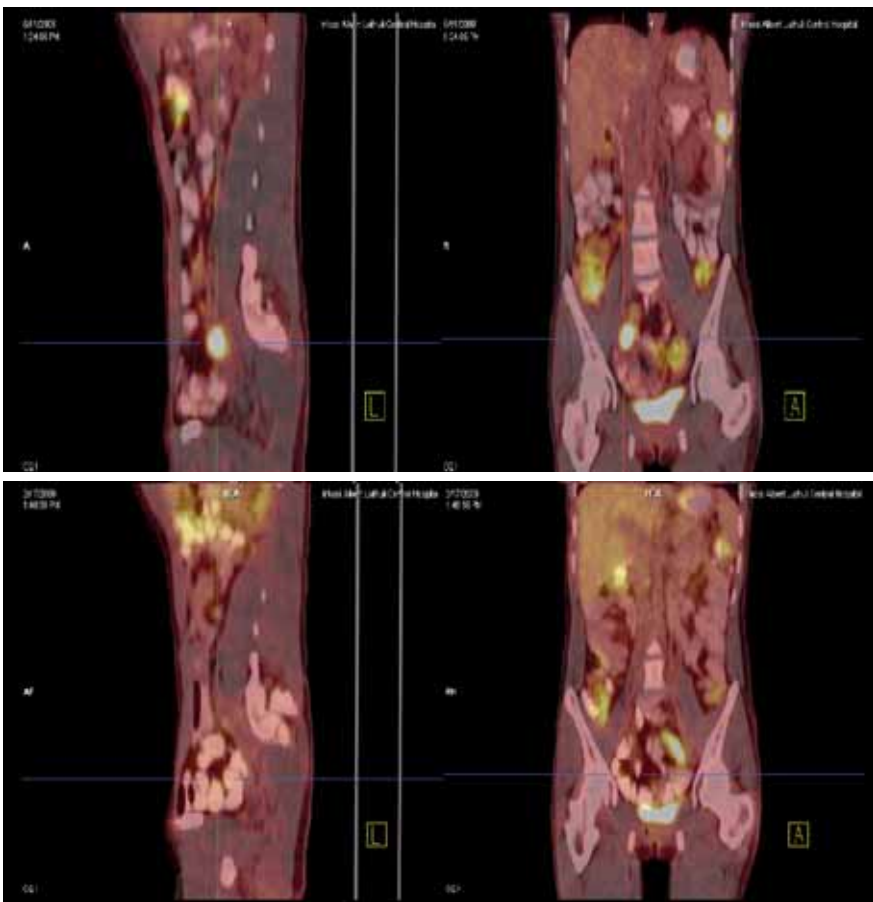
FDG- PET/CT scan image on presentation with FDG uptake noted in the right adnexal region.
